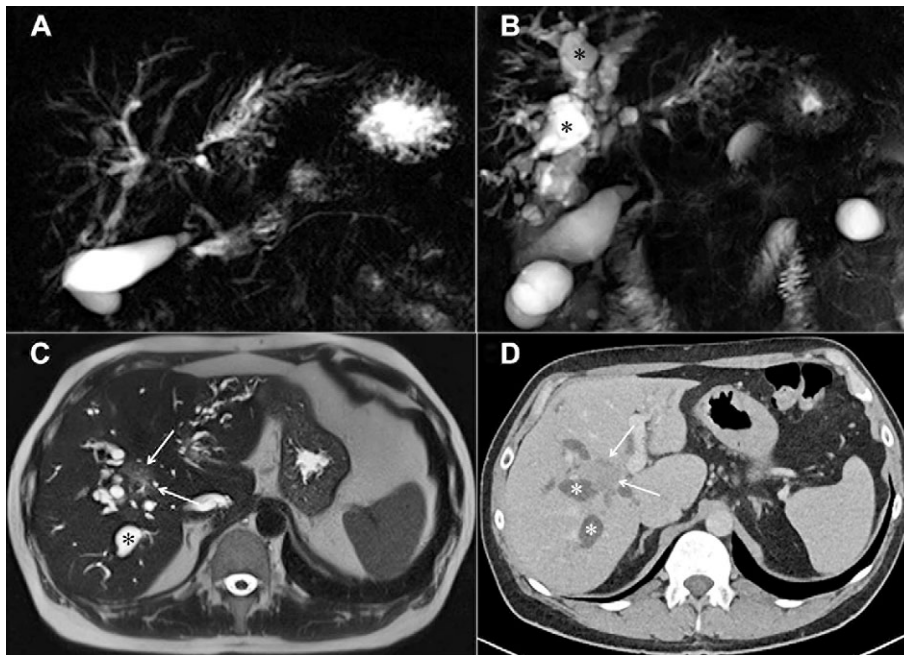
Cholangiocellular carcinoma in a 52-year old man with primary sclerosing cholangitis. Thick slab MRCP demonstrates multifocal alternating strictures and dilations of intrahepatic bile ducts (A). Follow MR examination after 5 years reveals worsening of dilatation (asterisk) in the right liver lobe (B). Axial T2-weighted image (C) in the same patient shows slightly hyperintense soft tissue mass (arrows) with intrahepatic bile duct dilatation (asterisk) in the right liver lobe, compatible with intrahepatic CCC. The corresponding CT image obtained in portal-venous phase shows the typical hypovascular enhancement of CCC (arrows) in comparison to normal liver parenchyma and bile duct dilatation (asterisks) (D).
